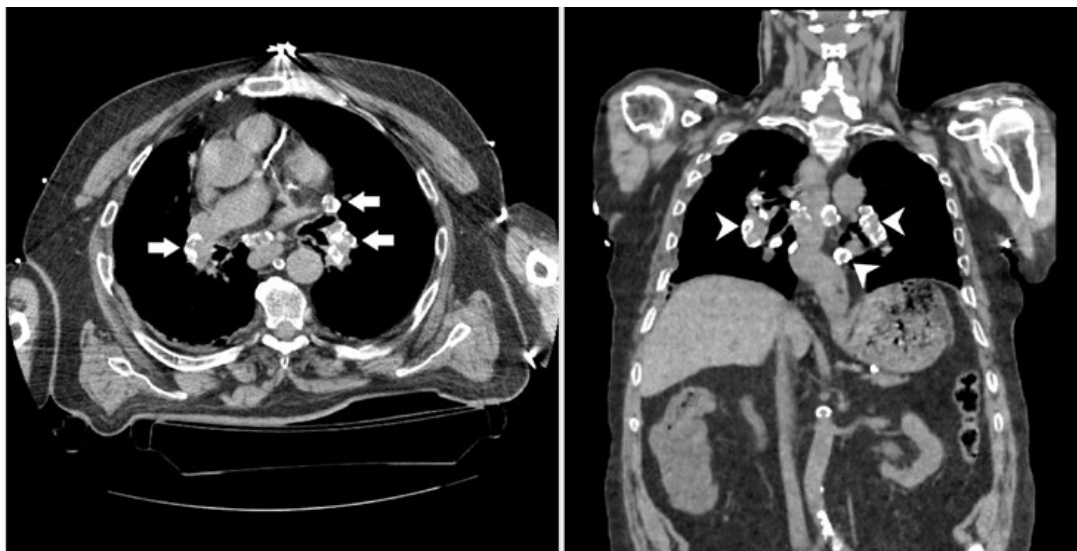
Computed tomogram of the chest (mediastinal window) showing the mediastinal and bilateral calcified hilar lymph nodes. The pattern of calcification is the classical eggshell calcification, a calcified rim around the periphery of the lymph nodes, shown by white arrows (left - axial view; right - coronal view).
